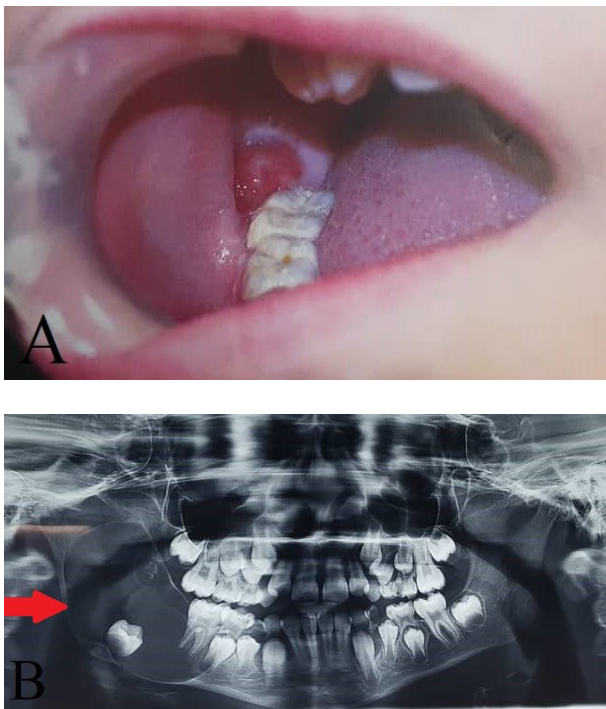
A: Intraoral view showing swelling on the right mandibular region, B: Panoramic x-ray revealed a well-defined unilocular radiolucent lesion involving the left side of mandible.
